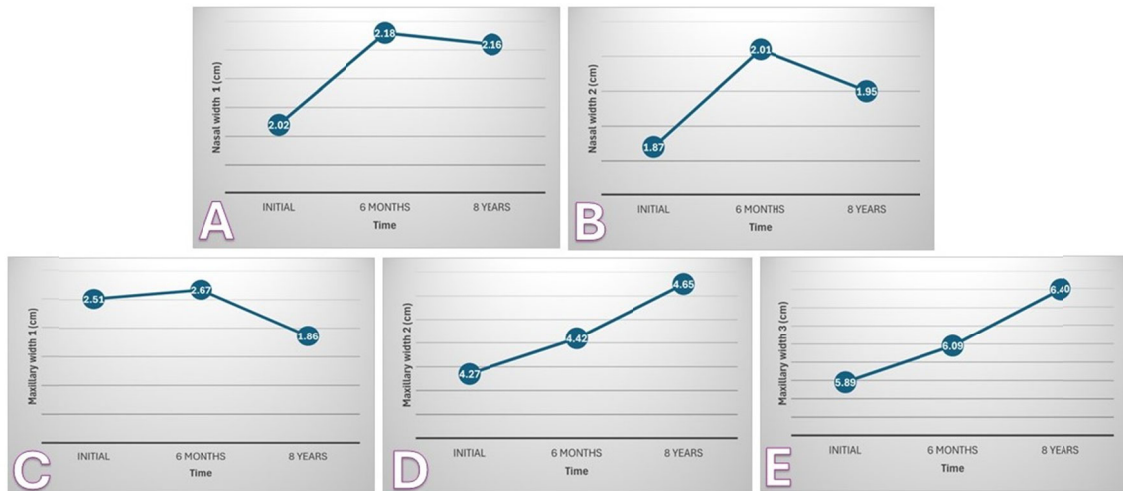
Graphs showing the CT mean measurements of nasal and maxillary transverse widths at initial time, 6 months after RME and 8 years after RME; A (nasal width 1); B (nasal width 2); C (maxillary width 1); D (maxillary width 2); E (maxillary width 3).
